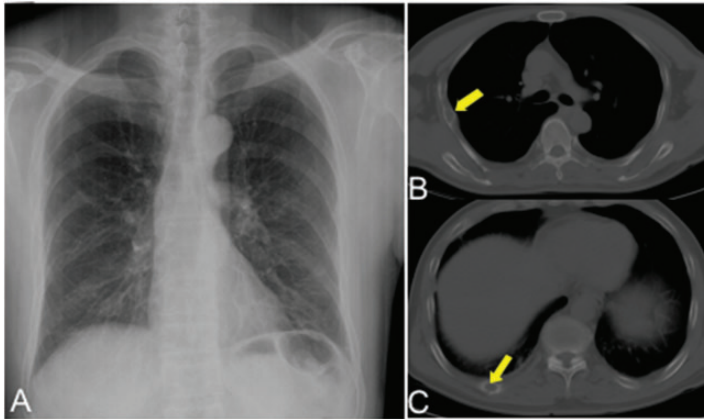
Standard posteroanterior X-ray (a) and computed tomography (b–c) of the chest.
